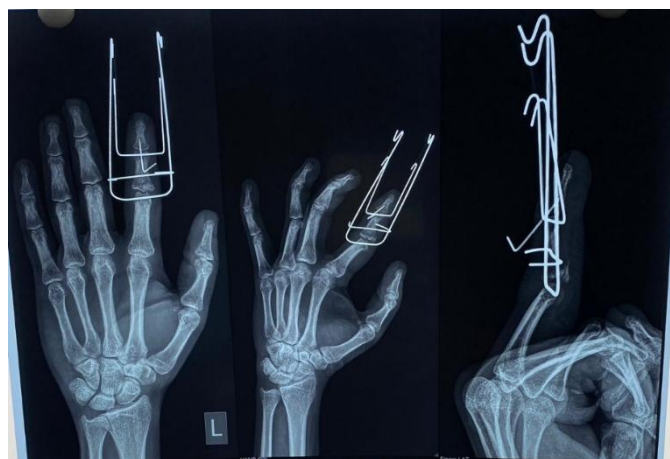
Post-operative follow up radiograph of left hand (AP, oblique & lateral views) following Suzuki frame fixation, showing maintained PIP joint alignment and satisfactory healing.
